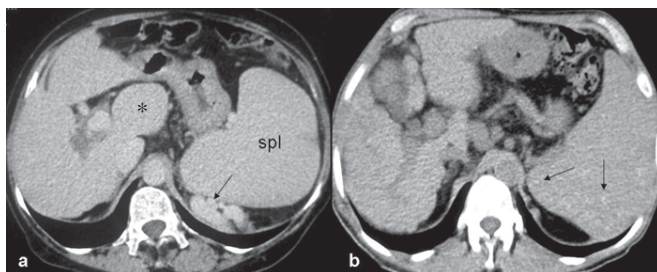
Contrast-enhanced CT (a) in a patient with cirrhosis and portal hypertension shows a hypertrophied caudate lobe (*), enlarged spleen (spl) and large lienorenal collaterals (arrow). In another patient with cirrhosis (b), diffusely nodular liver surface and high density, splenic Gamma Gandy bodies can be seen on a non-contrast CT (arrows).
